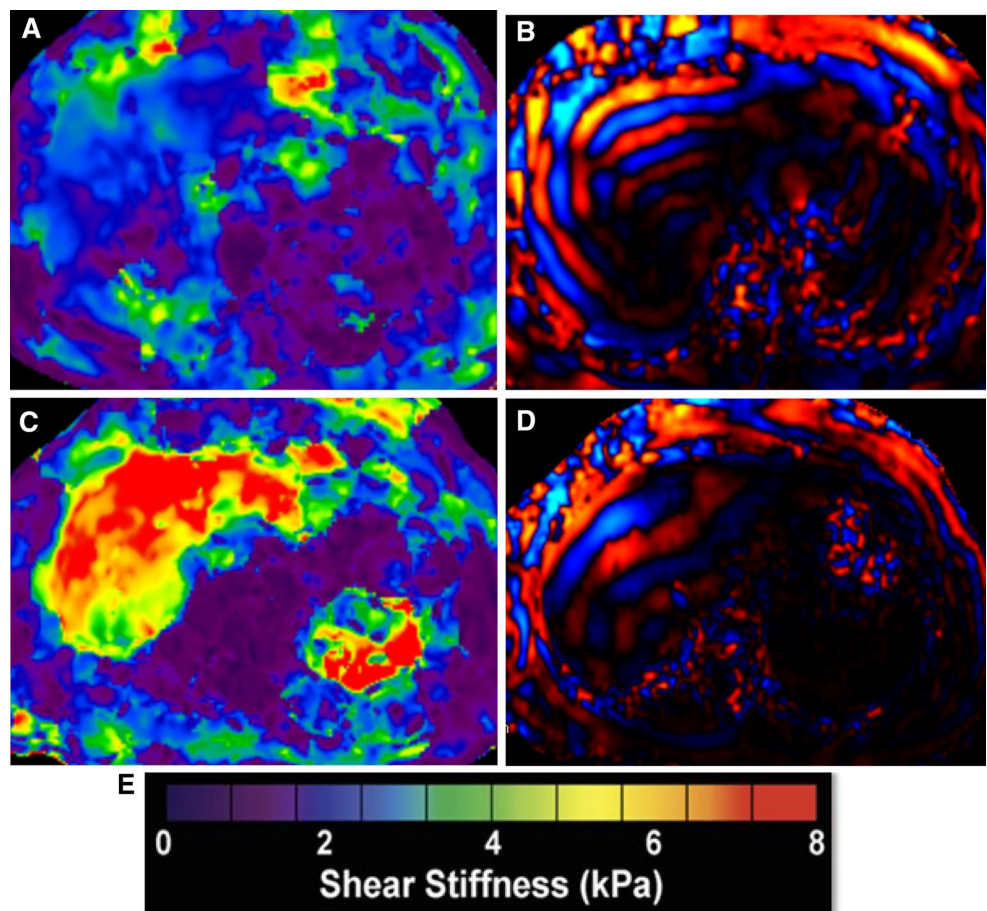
GI applications of MRI
